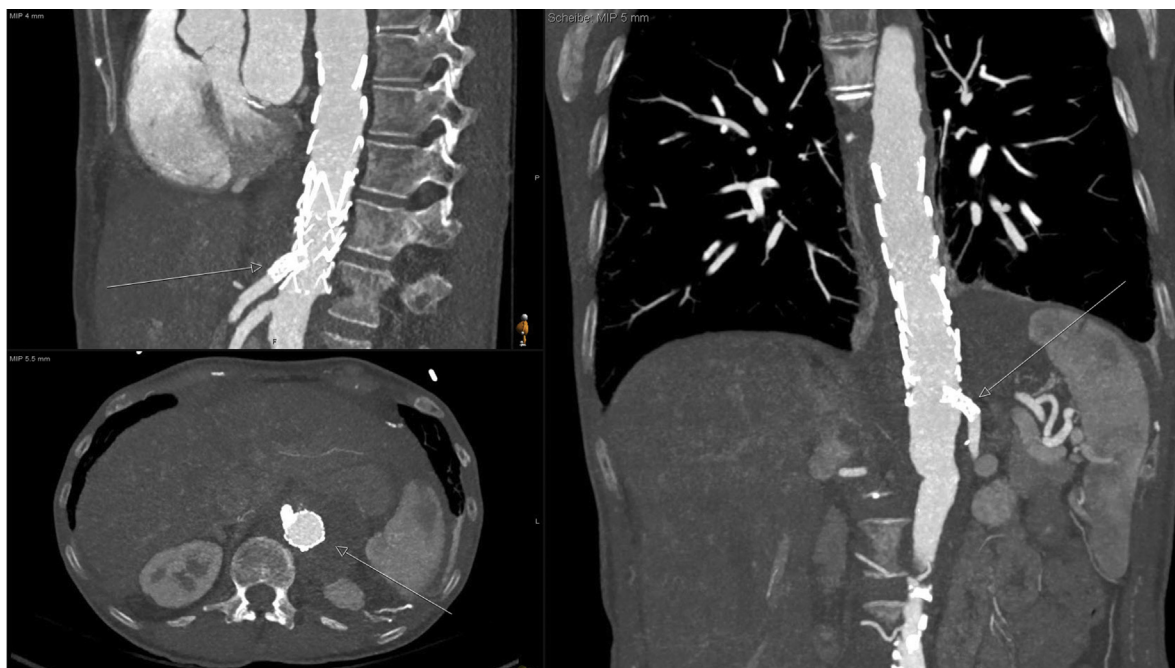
Postoperative computed tomography angiogram showing the correct position of the custom-made stent-graft and the stent-grafts for the celiac artery (*arrow*) and left renal artery (*arrow*) with complete aneurysm sealing (*arrow*) and no signs of an endoleak.
